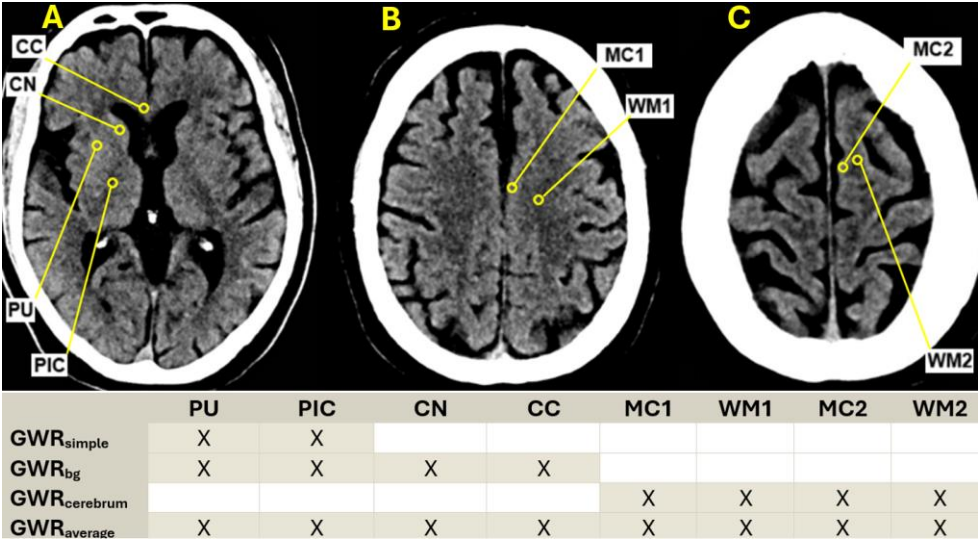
Attenuation measurements in specific grey- and white matter structures with approximately 0.1 cm² ROIs for GWR at three anatomical levels; A) the basal ganglia level, B) the centrum semiovale level, and C) the high convexity level. Various GWR models use different attenuation measurements marked with “X”. CT; head computed tomography, CC; genu corpus callosum, CN: head of the caudate nucleus, GWR grey- white matter ratio, MC1; medial cortex at the level of centrum semiovale, MC2; medial cortex at the high convexity level, PIC; posterior limb of the internal capsule, PU putamen, WM1; white matter at the level of the centrum semiovale, WM2; white matter at the high convexity level.
